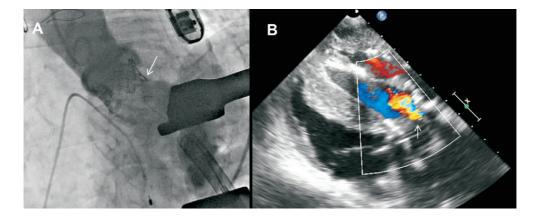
Assessment of aortic regurgitation (AR) after TAVI. Panel A shows supra-aortic angiography to estimate the AR grade. In contrast to echocardiography, angiography has limited resolution to differentiate between paravalvular and transvalvular AR. Panel B shows the TEE 120° transgastric view of the same patient. The arrow indicates the presence of a wide regurgitant jet in the valve due to a frozen cusp.
